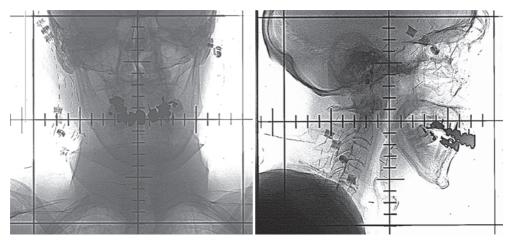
B.1 Orthogonal X-rays of a head and neck patient.
